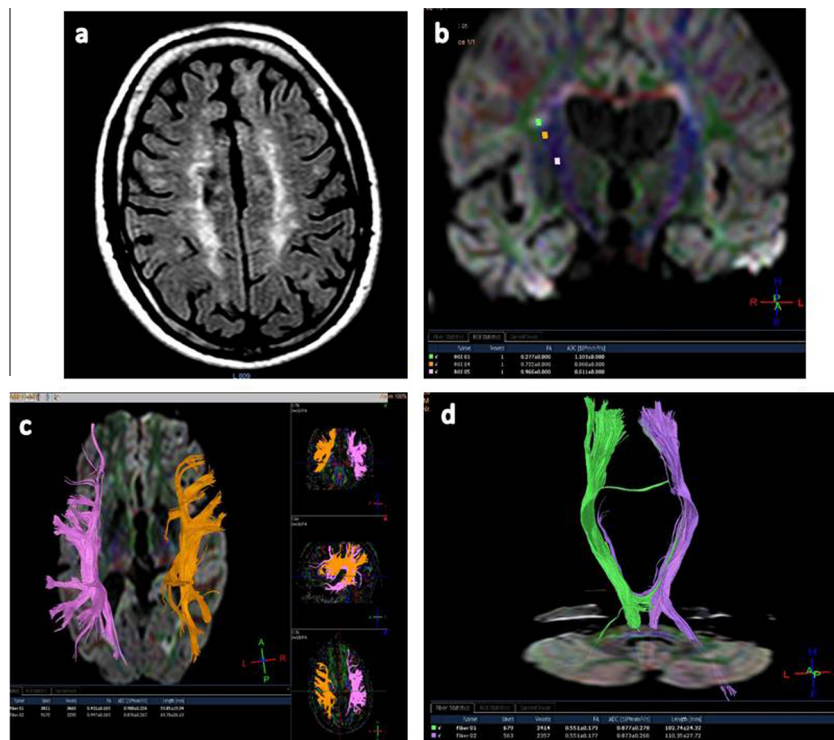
Male patient (49 years) (a) axial view FLAIR shows bilateral hyperintense lesions in periventricular WM. (b) Color-coded WM fiber maps of ROIs show: FA at ROI 1 measures 0.27 while MD 1.10 (c and d). Three-dimensional fiber tracts on CST on both sides generated on the basis of fractional anisotropy (FA measures 0.55 while MD 0.87).
